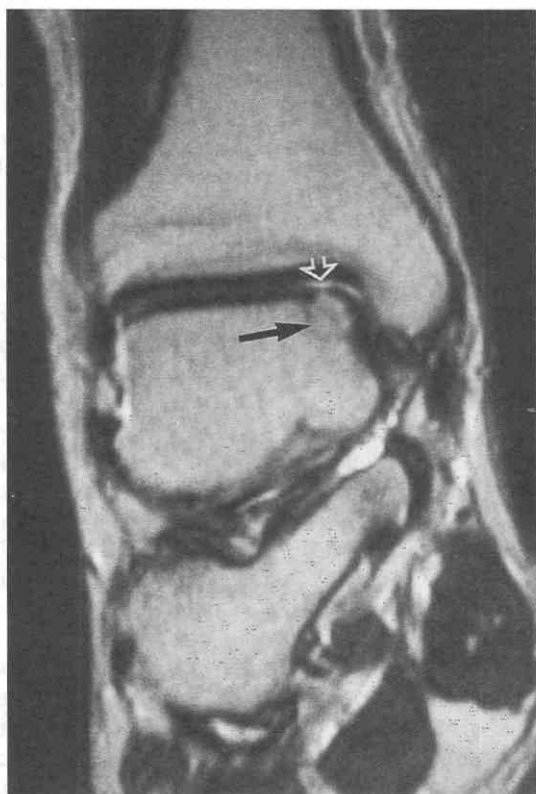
On this T2-weighted coronal image, an osteochondral defect is seen medially. The fragment is isointense to adjacent marrow, and no high signal rim is seen around it (*black arrow*). Therefore, there is no definite evidence of loosening. Disruption of the articular cartilage (*open arrow*) is noted; the fragment is thus considered loose in situ.
